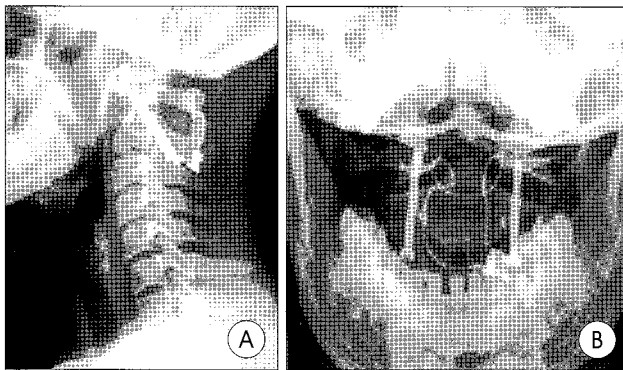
Lateral (A) and open-mouth (B) radiographs of the cervical spine indicating solid fusion with transarticular screw fixation and posterior C1-2 wiring.
